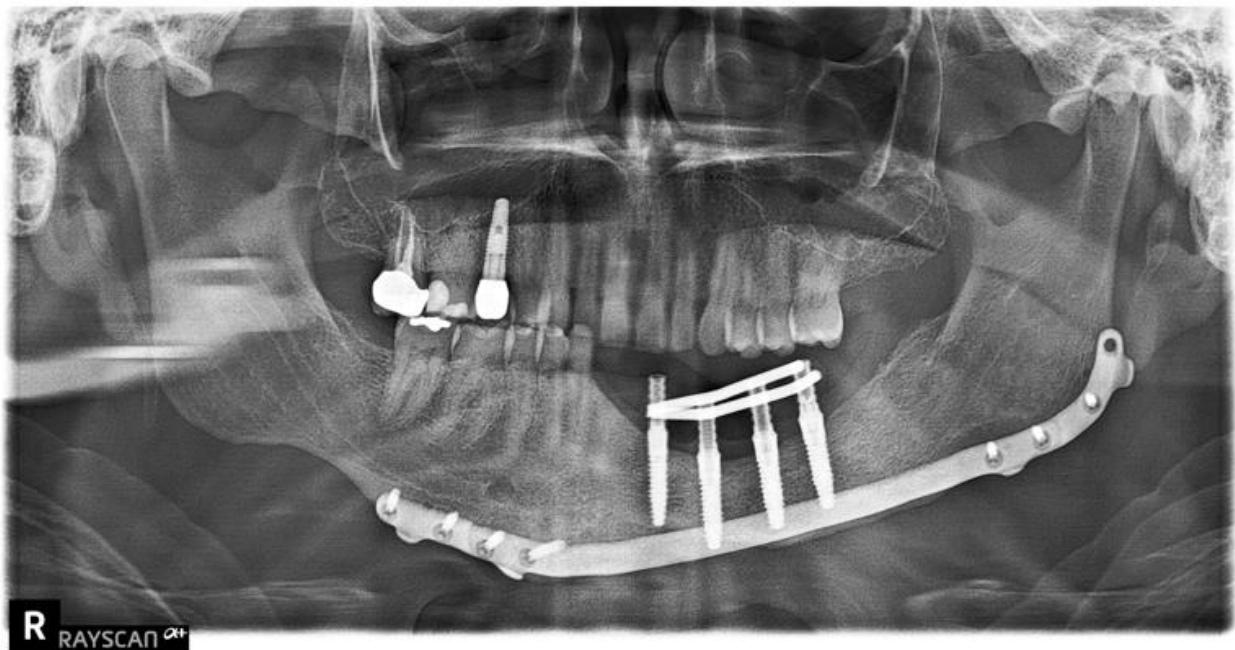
Radiographic confirmation of verification jig passive fit using a one-screw test.
